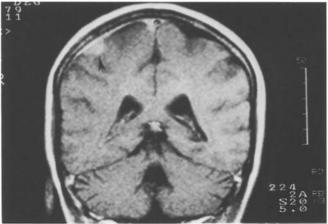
MRI of patient with breast cancer. Communicating 4 ventricles hydrocephalus was found after rapid deterioration of cognition and vigilance. Functions recovered after CSF shunting. CSF examination revealed malignant cells. *Arrow*, linear meningeal enhancement of doubtful diagnostic meaning
